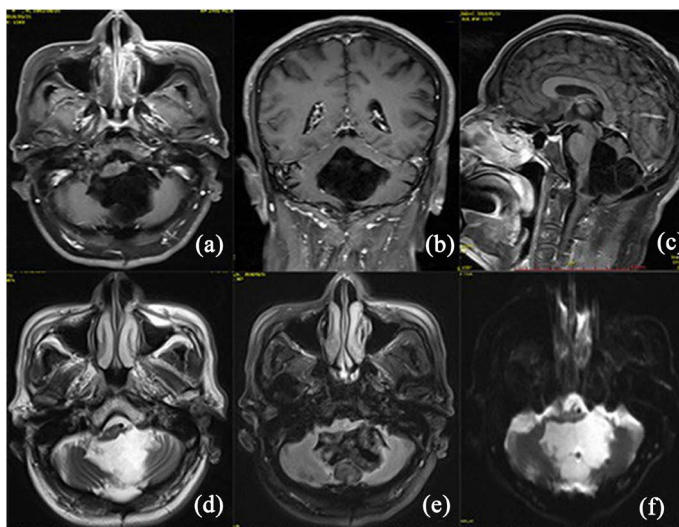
Axial position. (a) Coronal position. (b) Sagittal position. (c) T1WI shows that the tumor is located in the cerebellar palsy and the fourth ventricle, showing a low-density signal, with irregular medium signal shadows visible, and the brain stem is obvious. Deformed under pressure. (d) Shows that the tumor shows a high signal in the axial T2WI image, and the signal intensity in the tumor cavity is not uniform. (e) The axial position T2Flair resembles a high-low mixed-density signal in which the tumor appears to be flocculated. (f) DWI image shows a high signal of mixed density in the tumor area
